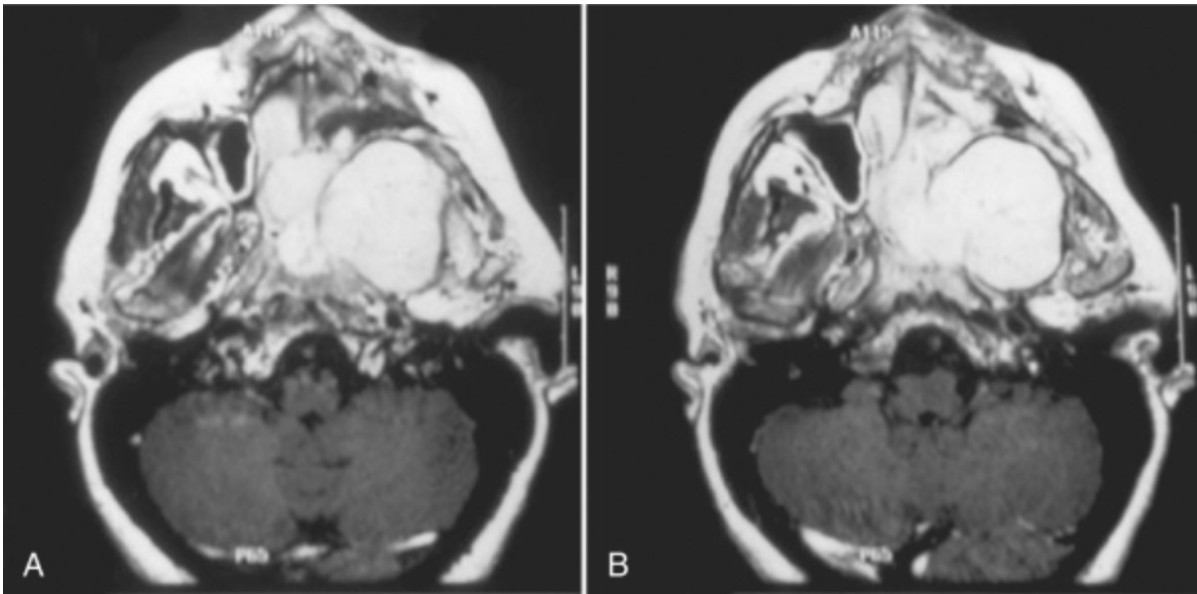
A and B, Computed tomography scans demonstrating a large ameloblastic fibrosarcoma of the left maxilla with extension into the infratemporal fossa. The anterior transfacial approach is ideally suited for excision of such lesions.
